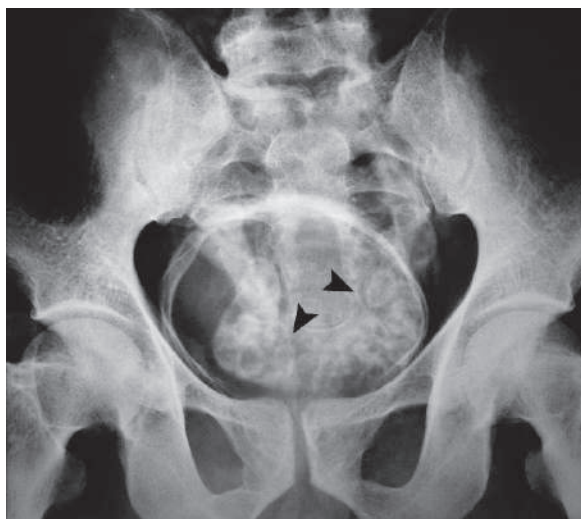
Plain radiograph of the pelvis shows complete calcification of the bladder with the seminal vesicles (*arrowheads*) in a patient with bilharziasis
